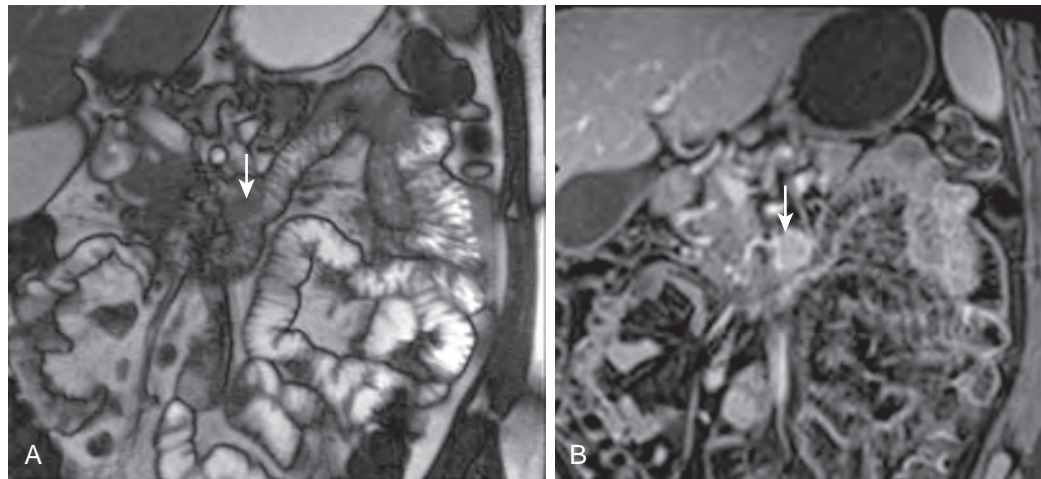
MR enterography of jejunal gastrointestinal stromal tumor in 55-year-old patient with unexplained gastrointestinal bleeding. A. Coronal true FISP image shows lobulated mass that arises from a jejunal loop, with smooth borders and extraluminal growth (*arrow*), suggesting submucosal origin of the neoplasm. B. Coronal contrast-enhanced, fat-saturated, T1-weighted VIBE image shows homogeneous enhancement of the mass (*arrow*).
